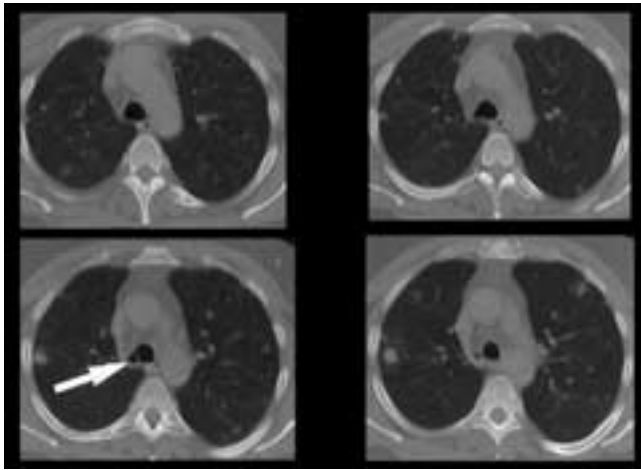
Right tracheal bronchus. Contiguous axial CT images through the upper thorax demonstrate an anomalous right upper lobe bronchus (*arrow*) arising directly from the trachea in this patient with metastatic bladder carcinoma.
